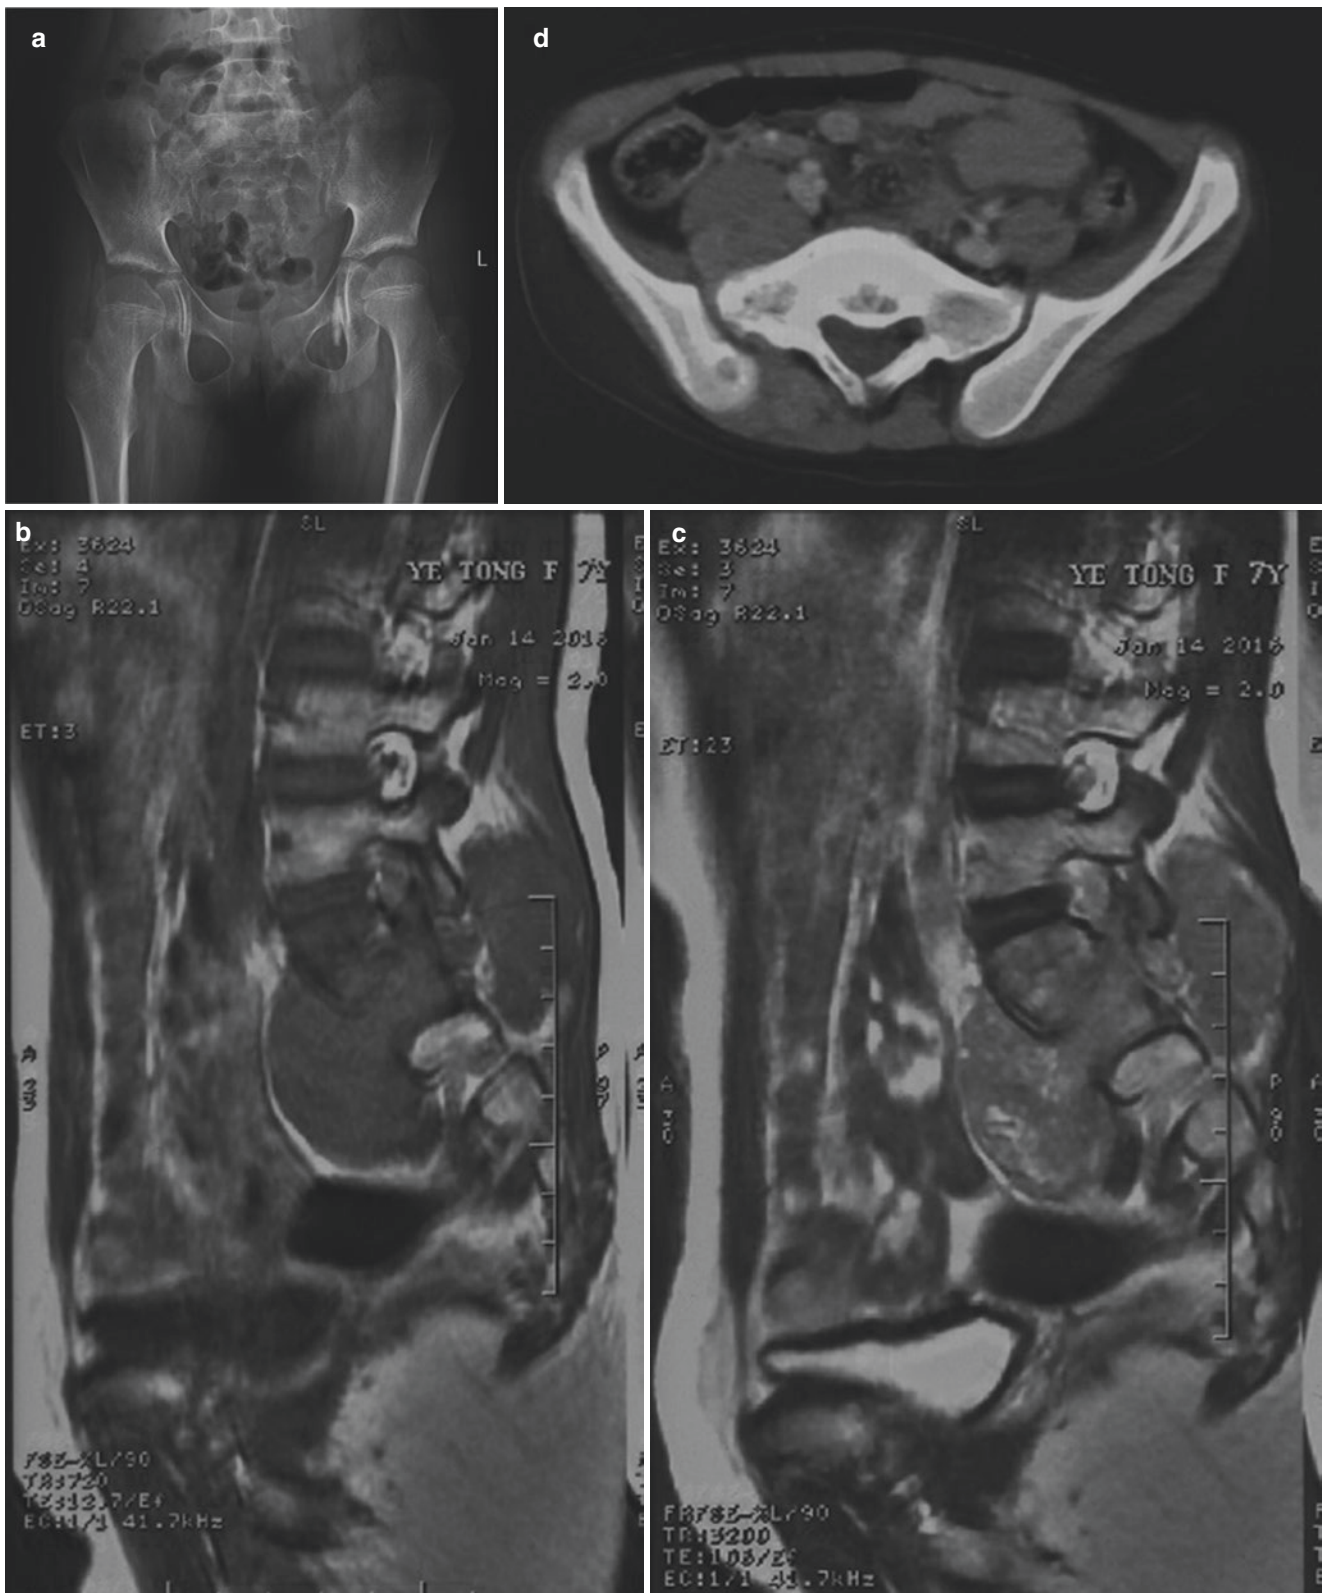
Radiological studies acquired in a 6-year-old girl. (a) Anteroposterior radiographs of the sacrum revealing sclerosis of the right side of S1–2. There are no permeative or destructive changes seen. (b–d) MRI and CT scan, however, demonstrated that there is both an
